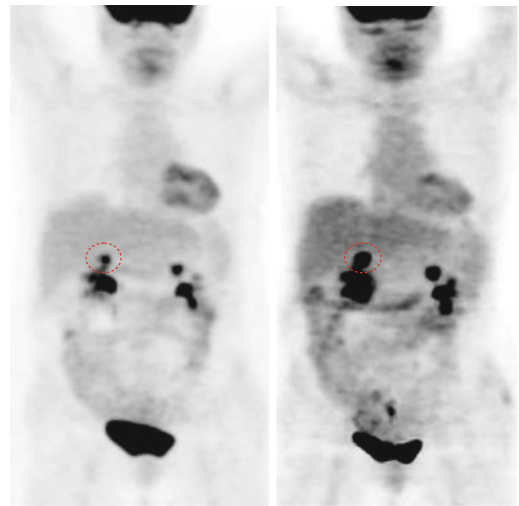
MIP image with different intensities of printing: The pathological FDG concentration of the mass is masked by the physiological renal excretion
